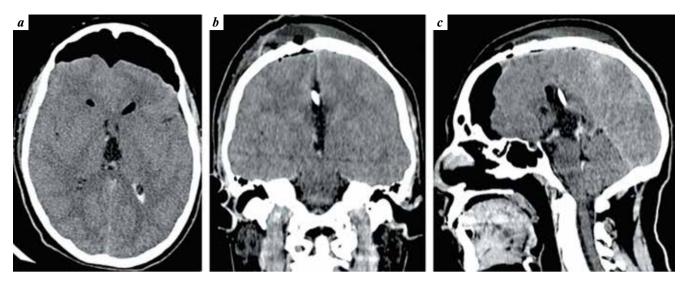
Brain multi-spiral computed tomography, post-operative day 1: a-axial view; b-coronal view; c-sagittal view. Total resection of the tumor. Post-operative no tension pneumocephalus. Ventricular drainage was inserted in the cavity of the third ventricle. There are no signs of hemorrhagic, ischemic complications. The lateral ventricles are not dilated, VKR-2=15%
